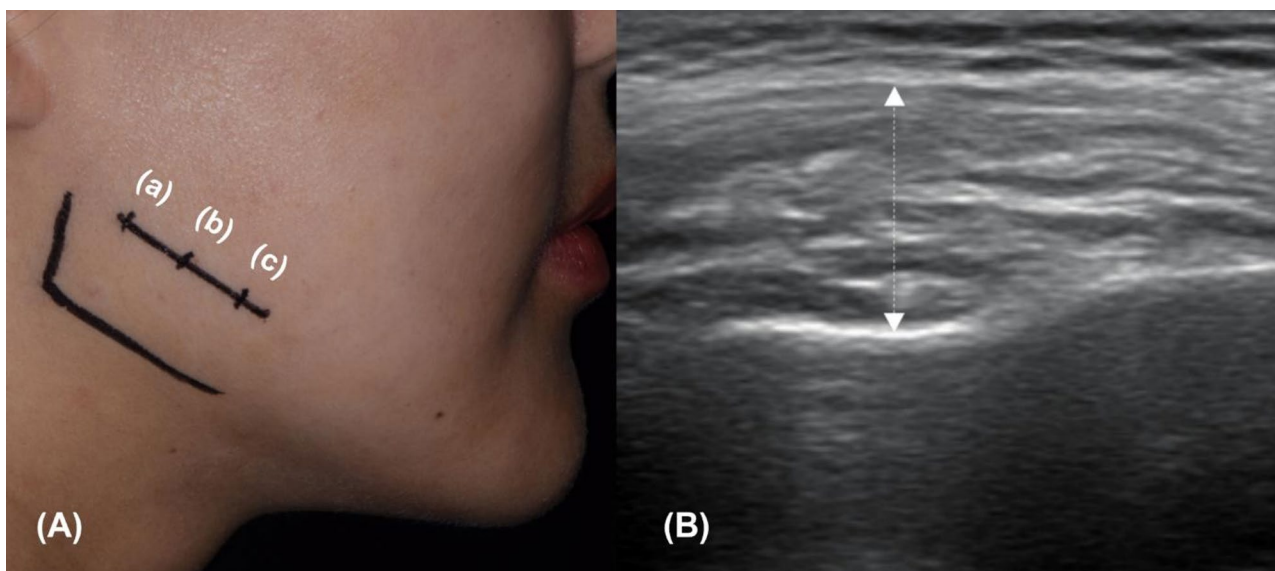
Assessment of masseter muscle thickness using ultrasound. A Ultrasound scanning sites for the superficial portion of the masseter muscle. Muscle thickness was measured at three sites along the posterior border of the mandibular ramus, spaced 1 cm apart and positioned 2 cm above the inferior border of the mandible: (a) posterior masseter area (PMA), (b) middle masseter area (MMA), and (c) anterior masseter area (AMA). B White arrow line indicates muscle thickness
